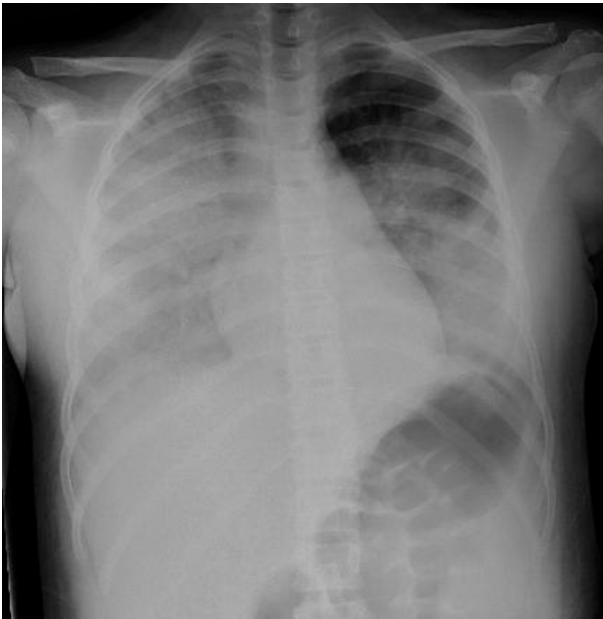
Chest X-ray, hospital day 1 showing signs of worsening acute respiratory distress syndrome (ARDS).
